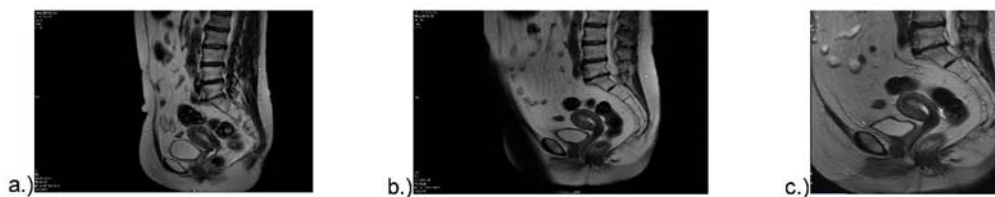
Control MRI of the patient: 1 months after oncothermia (a), one year after oncothermia (b), four years after oncothermia (c)
